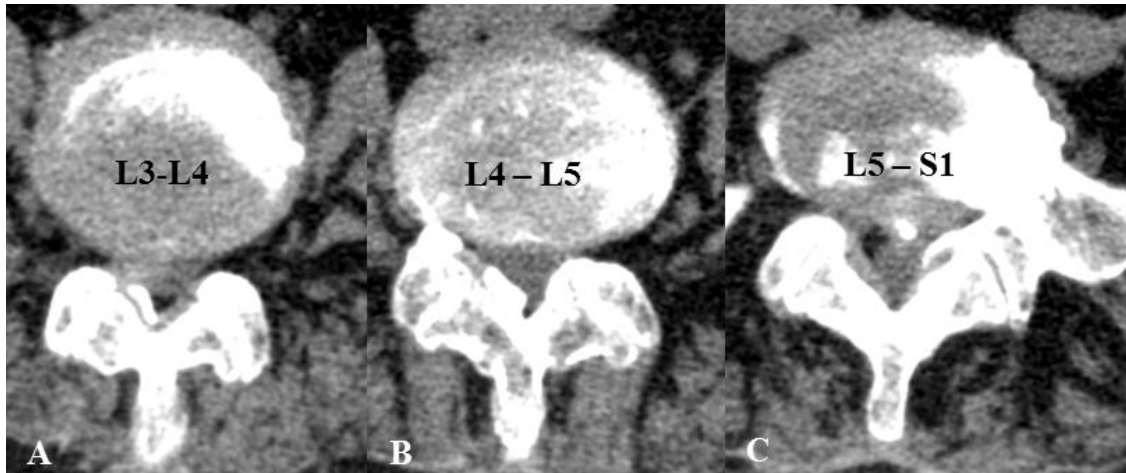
CT images in a patient with: A/ right paramedian L₃-L₄ disc herniation; B/ right lateral stenosis at L₄-L₅ level; C/ median L₅-S₁ disc herniation
